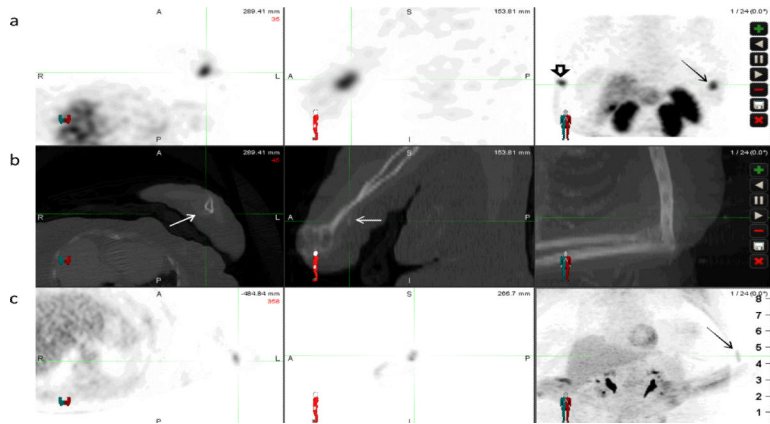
66 year old female with tumor induced osteomalacia. Row (a) displays SPECT images (axial, sagittal, and Maximum pixel Intensity Projection (MIP)) obtained 4-hours after the injection of 6.5mCi ^{111}In - DPTA-pentetreotide; row (b) displays the transmission CT from that study; row (c) displays PET scan acquired 1-hour post injection of 14.4mCi of ^{18}F -FDG. The intense focal uptake in the distal left arm (cross hairs and solid arrow) on the ^{111}In - DPTA-pentetreotide SPECT images, which corresponds to faint soft tissue calcifications on the transmission CT, shows only mild uptake on the ^{18}F -FDG PET images. (Open arrow indicates injection site)
